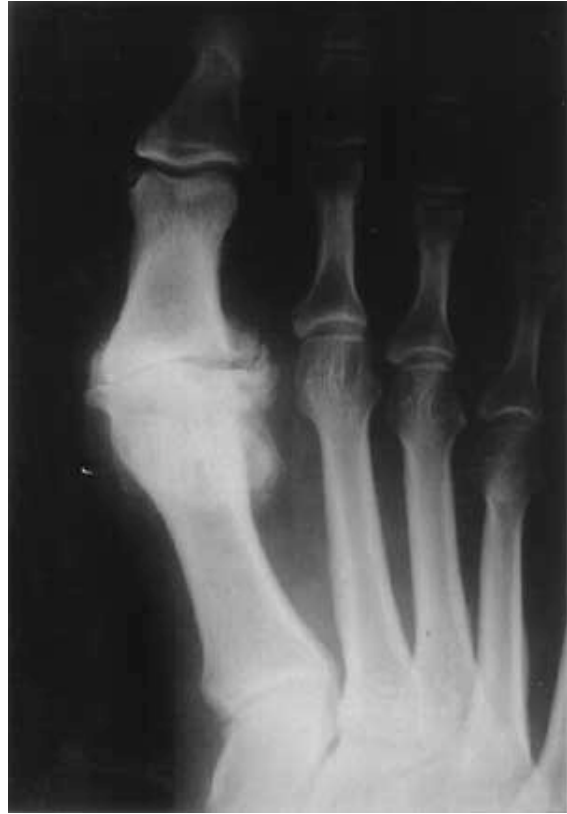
Stage III hallux rigidus with complete destruction of the metatarsophalangeal joint. a) On the dorsoplantar radiograph, the joint is completely obliterated. Osteophytes are present at the lateral and medial aspect of the first metatarsal head.
